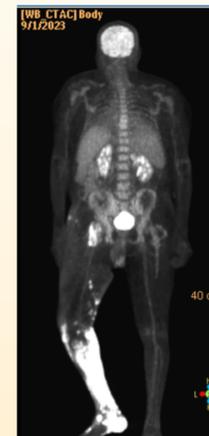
PET/CT tumor imaging (FDG) Uptake noted to left midfoot, extending to mid-distal thigh. Increased uptake also noted left inguinal region and left deep inguinal lymph nodes.
